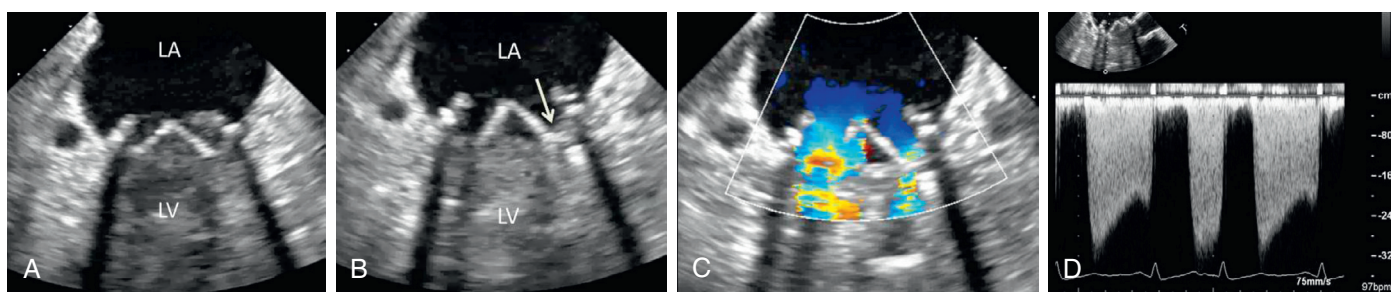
■ Transesophageal echocardiogram of a thrombosed bileaflet mechanical mitral valve in a 43-year-old female who stopped anticoagulation for a dental procedure with inadequate bridging. In systole (A), the bright occluder can be seen in a closed position, causing reverberation artifact into the left ventricle (LV). During diastole (B), there is a minimal opening of the occluder (*white arrow*) from the acute thrombus. Color-flow Doppler (C) shows flow primarily through only one side of the valve, while there is only a very narrow jet at the site of the stuck leaflet. Continuous-wave Doppler (D) estimated a severely elevated mean gradient of 24 mm Hg, and the patient required emergent surgical valve replacement with a bioprosthesis.
